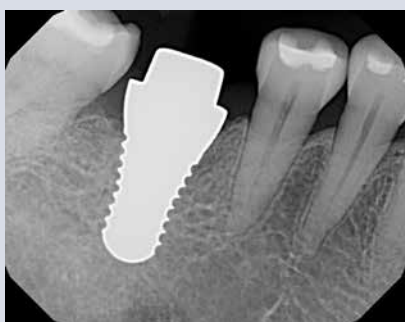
Radiograph showing bone volume after four-months of healing.
